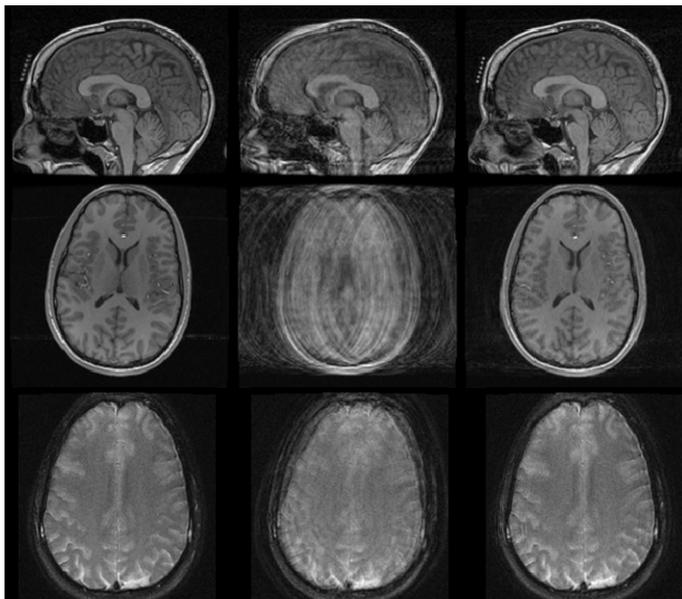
In-vivo results using the self-encoded marker. 3D SPGR sagittal (top row), axial (middle row) and T2-weighted spiral (bottom row) images are shown. For all cases, patient motion causes significant artifacts on the data (middle column). These are removed by the optical tracking system (right column). Reference images are shown on the left column.
